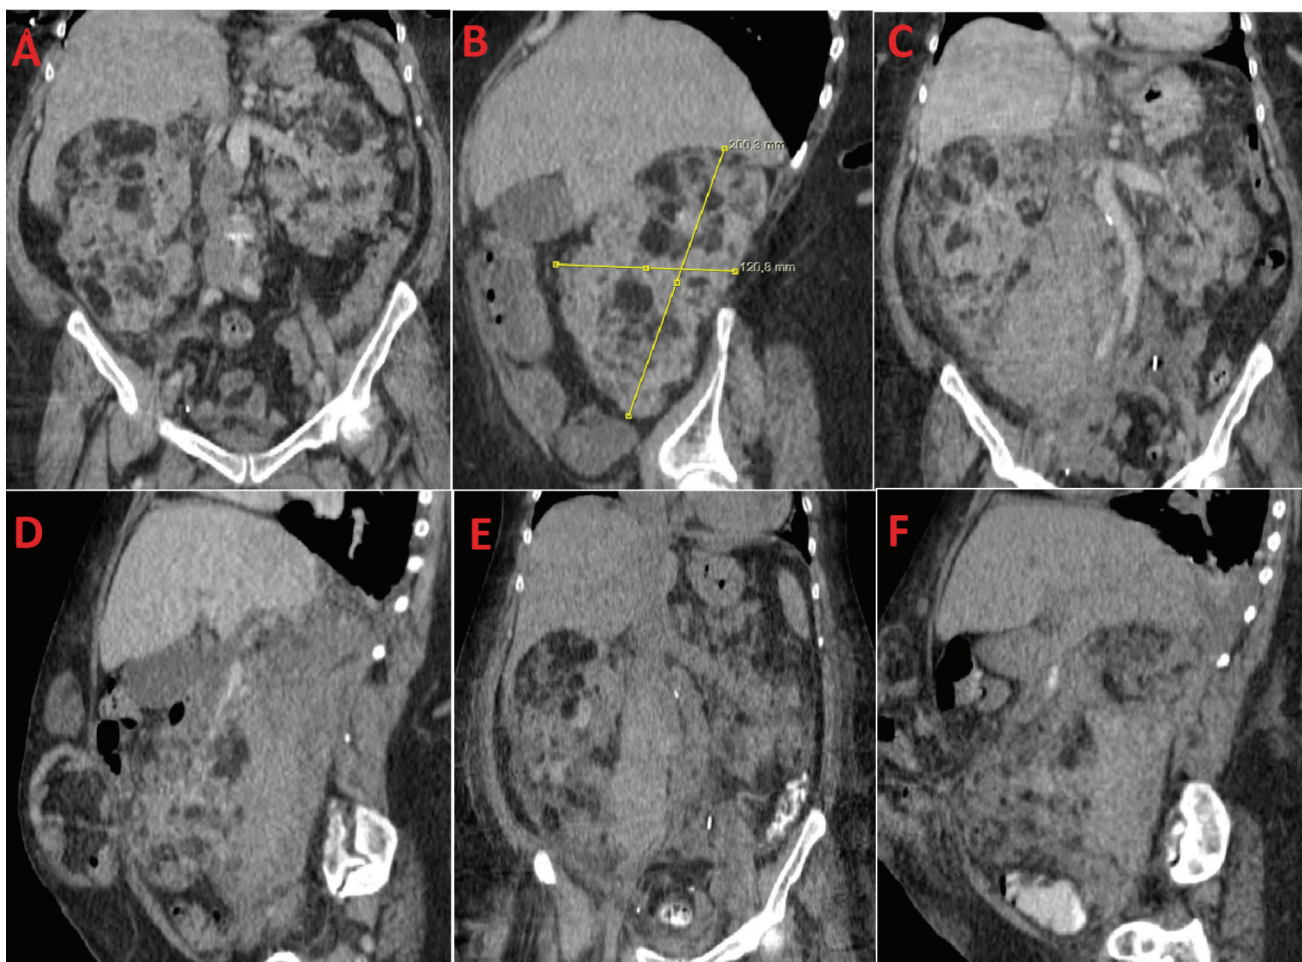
A) Image of bilateral giant angiomyolipomas on computed tomography (CT) of 2019. B) Image of right giant angiomyolipoma on CT of 2019. C) Retroperitoneal hematoma image due to bleeding thought to originate from right giant angiomyolipoma on the CT performed at the emergency admission of the patient. D) Hematoma image in the retroperitoneal area on CT performed at the emergency admission of the patient. E) On the CT which performed on the 4th day after selective arterial angioembolization (SAE), it is observed that the retroperitoneal hematoma size is decreasing (coronal section). F) On the CT which performed on the 4th day after SAE, it is observed that the retroperitoneal hematoma size is decreasing (sagittal section)
